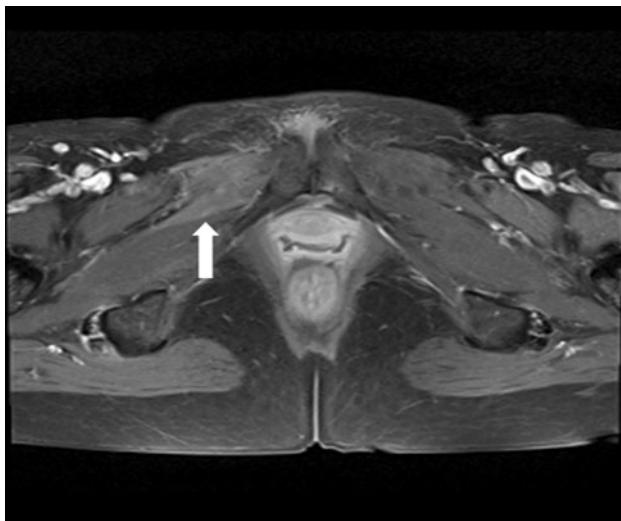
The partially visualized right adductor muscles show high signal intensities (white arrow) on postcontrast fat-suppressed T1-weighted magnetic resonance images
